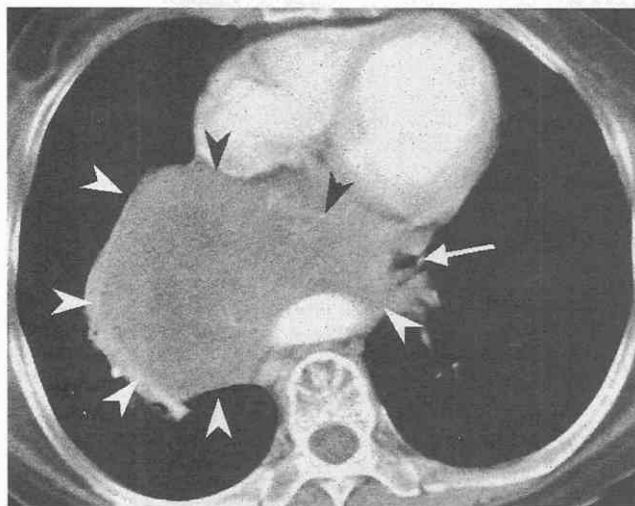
Leiomyosarcoma of the esophagus. CT scan shows a large mass (arrowheads) with heterogeneous enhancement. Despite the large size of the tumor, the esophageal lumen (arrow) is merely displaced but not collapsed.
